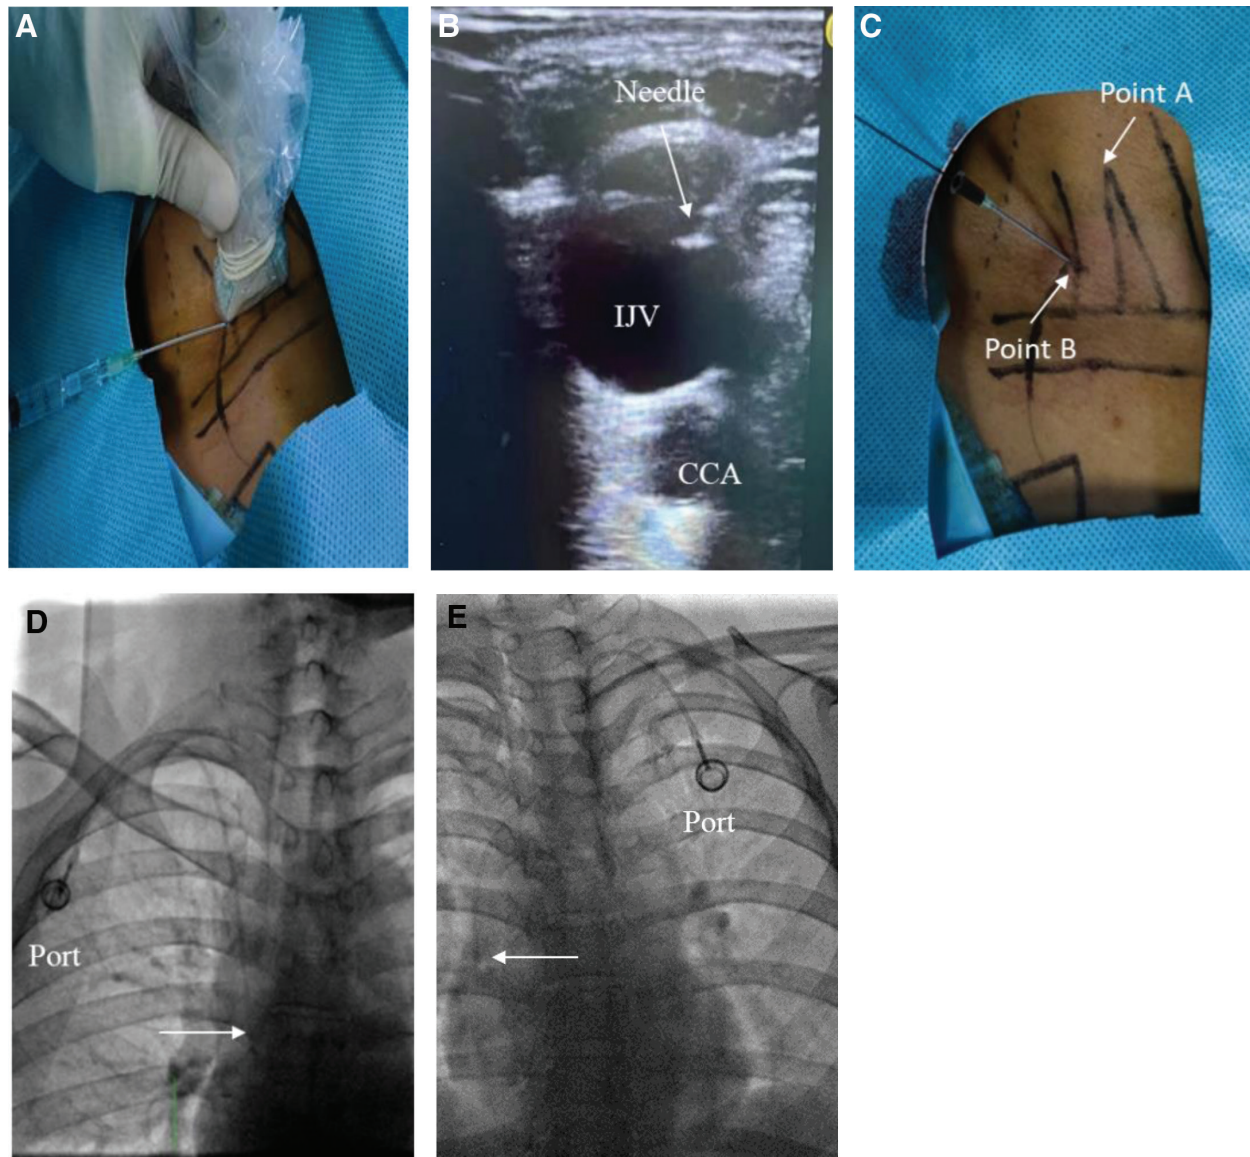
Images of ultrasound-guided TIVAP implantation via the posterior approach of the internal jugular vein. A, Short axis, lateral in-plane technique; it allows simultaneous view of the full length of the needle, the IJV, CA, and adjacent tissue. B, The ultrasound-guided successful puncture of the IJV needle insertion (white arrow) using short axis, lateral in-plane technique. C, Puncture needle was inserted at the posterior triangle. Point A is the puncture site of middle approach and point B is the puncture site of posterior approach. D, A TIVAP is implanted via the posterior approach of right IJV, crossing over the right clavicle. The port is located on the right chest wall, and the tip of the catheter (white arrow) is located at the junction of the superior vena cava and the right atrium. E, A TIVAP is implanted via the posterior approach of left IJV, crossing over the left clavicle. The port is located on the left chest wall, and the tip of the catheter (white arrow) is located at the junction of the superior vena cava and the right atrium. CA = carotid artery; CCA = common carotid artery; IJV = internal jugular vein; TIVAP = totally implantable venous access port.
